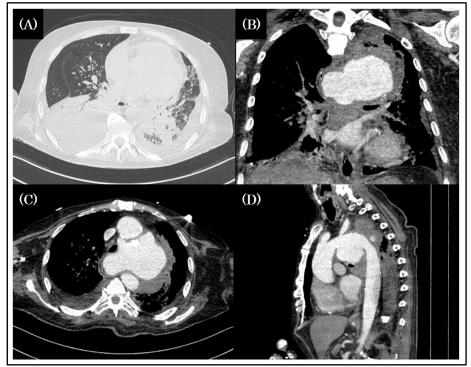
Follow-up chest CT demonstrating further disease progression (8 April 2025). (A) Axial lung window shows persistent multilobar necrotizing consolidation with cavitary changes. (B) Coronal reconstruction demonstrates near-complete resolution of the right shoulder abscess after surgical drainage. (C–D) Contrastenhanced axial and sagittal reconstructions reveal continued enlargement of the mycotic aneurysm of the aortic arch
